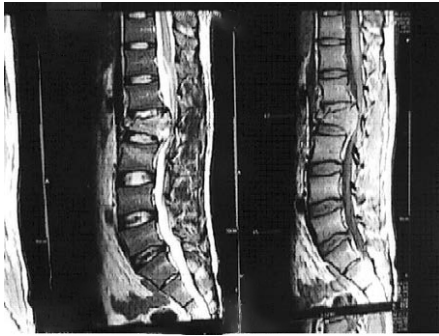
MRI showing compression & burst fractures
